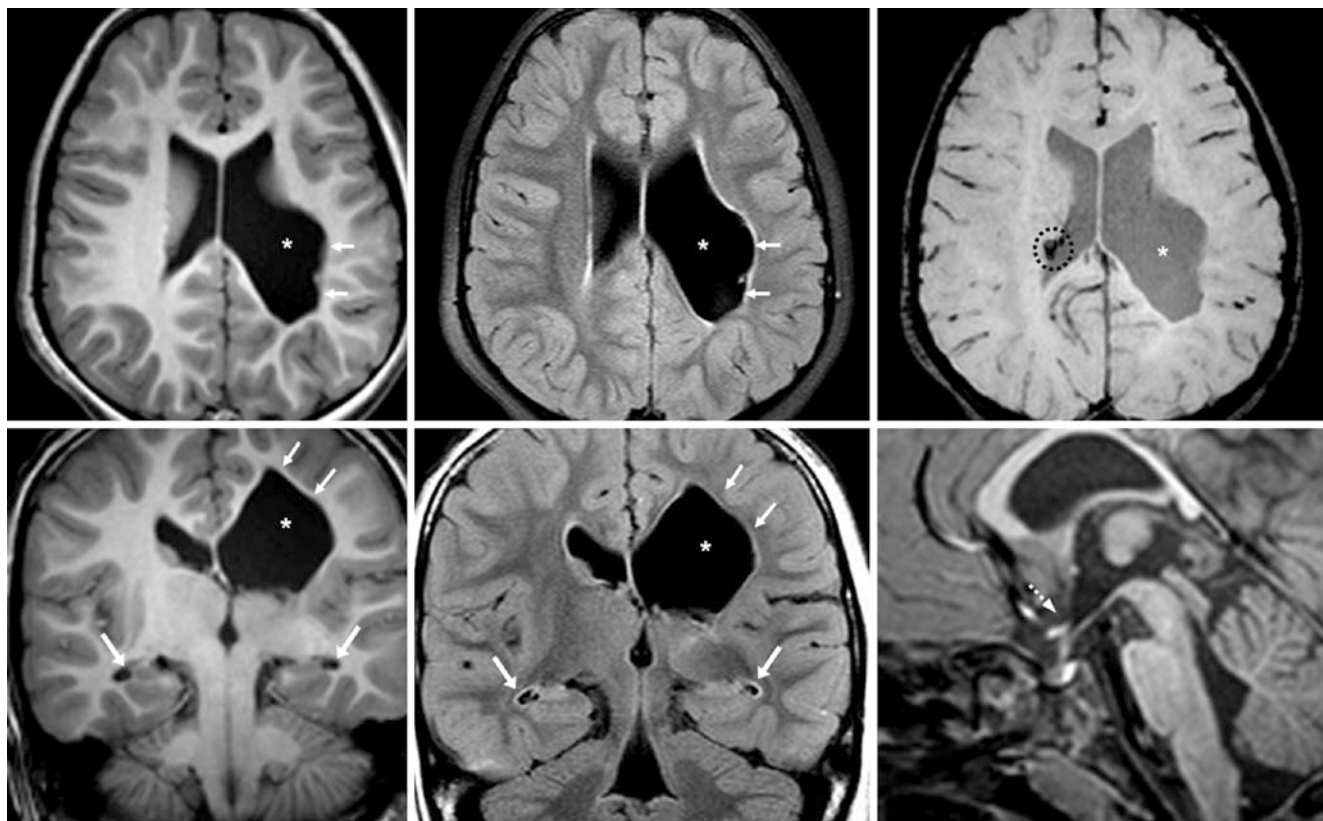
Comparison case of PVL. A 5 year old who underwent a 3T MRI had an enlarged left lateral ventricular posterior body (*) on axial T1WI (top left), FLAIR (top middle), and SWI (top right), with thinned PVWM (thin arrows). The findings are also shown on coronal T1WI (bottom left), FLAIR (bottom middle), and sagittal T1WI (bottom right). SWI depicts a tiny germinal matrix hemorrhage (dotted circle). The normal optic recess (dotted arrows) excludes hydrocephalus
